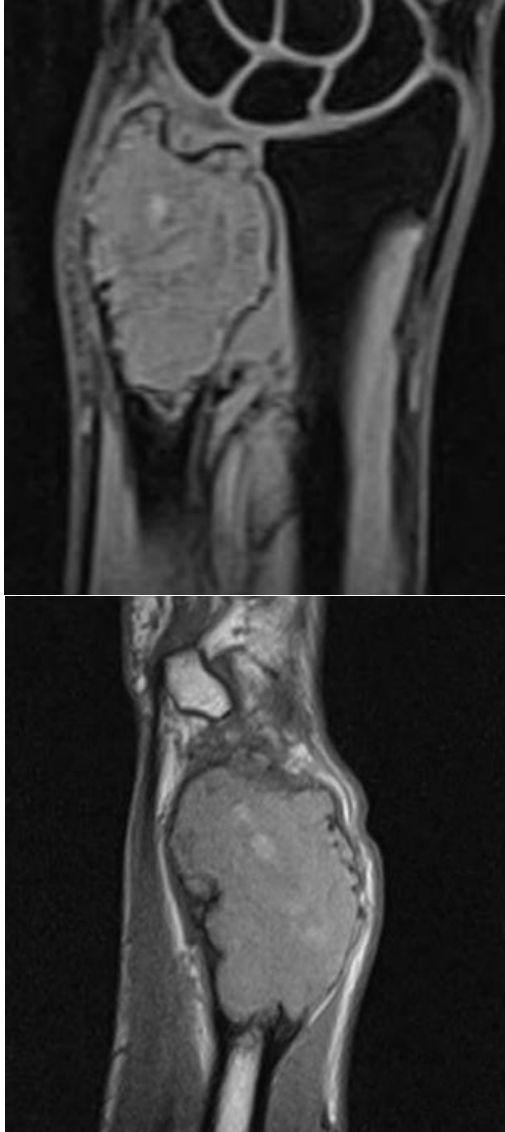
MRI showed heterogeneously enhancing solid area and peripherally enhancing cystic area containing fluid-fluid level within in distal part of right ulna reaching upto articular surface
